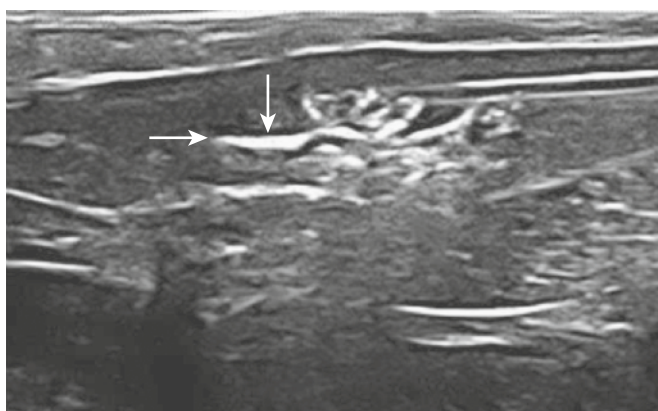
Bubbles of air (arrows) are rarely seen in a musculoskeletal ultrasound examination. They can appear after a traumatic event or in a septic condition. Air bubbles can produce an image similar to a ring-down artifact.
